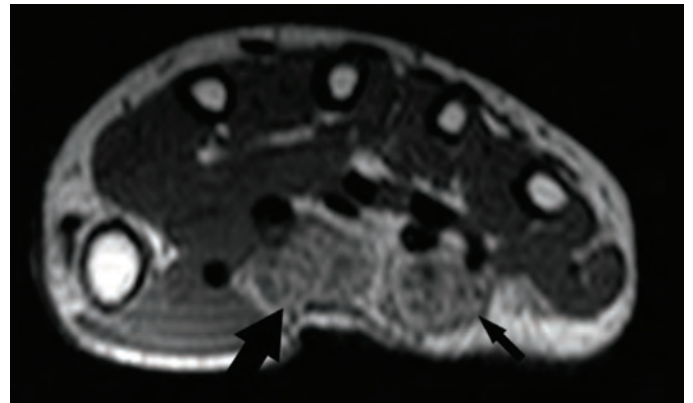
An 11-year-old girl with LFH of the median and ulnar nerves. Axial T1-weighted images through the wrist. The coaxial cable-like appearance of both the median (thick arrow) and ulnar nerve (thin arrow)
